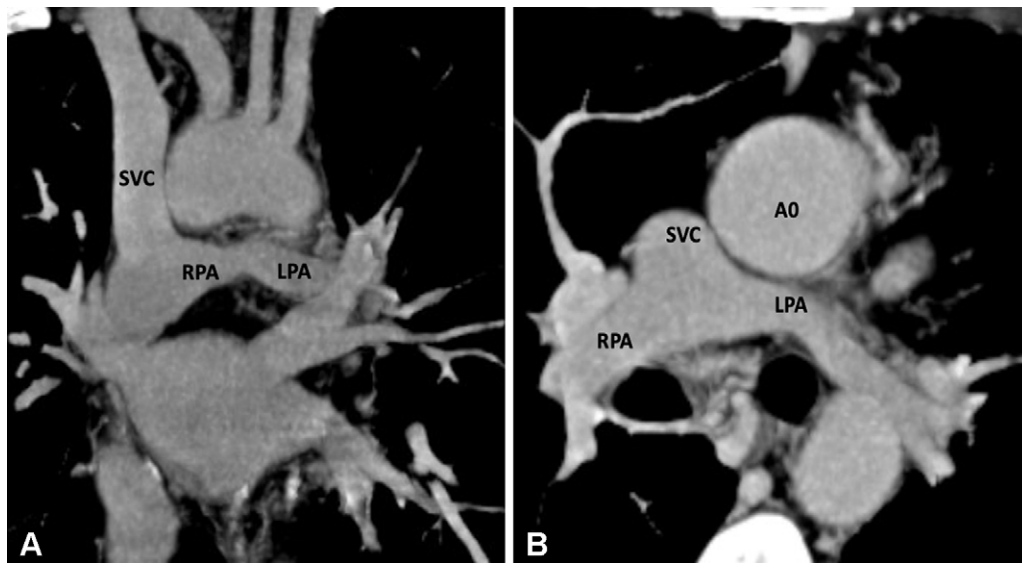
Postoperative appearance of DORV with functional single ventricle after bidirectional cavopulmonary shunt in a 31-month-old boy. (A) Coronal oblique and (B) axial maximum intensity projection CT images show end-to-side anastomosis of the superior vena cava to the right pulmonary artery after division of the superior cavoatrial junction. In this patient, bidirectional cavopulmonary shunt was performed as an intermediate procedure to staged Fontan operation. Ao = aorta, DORV = double-outlet right ventricle, LPA = left pulmonary artery, RPA = right pulmonary artery, SVC = superior vena cava.
